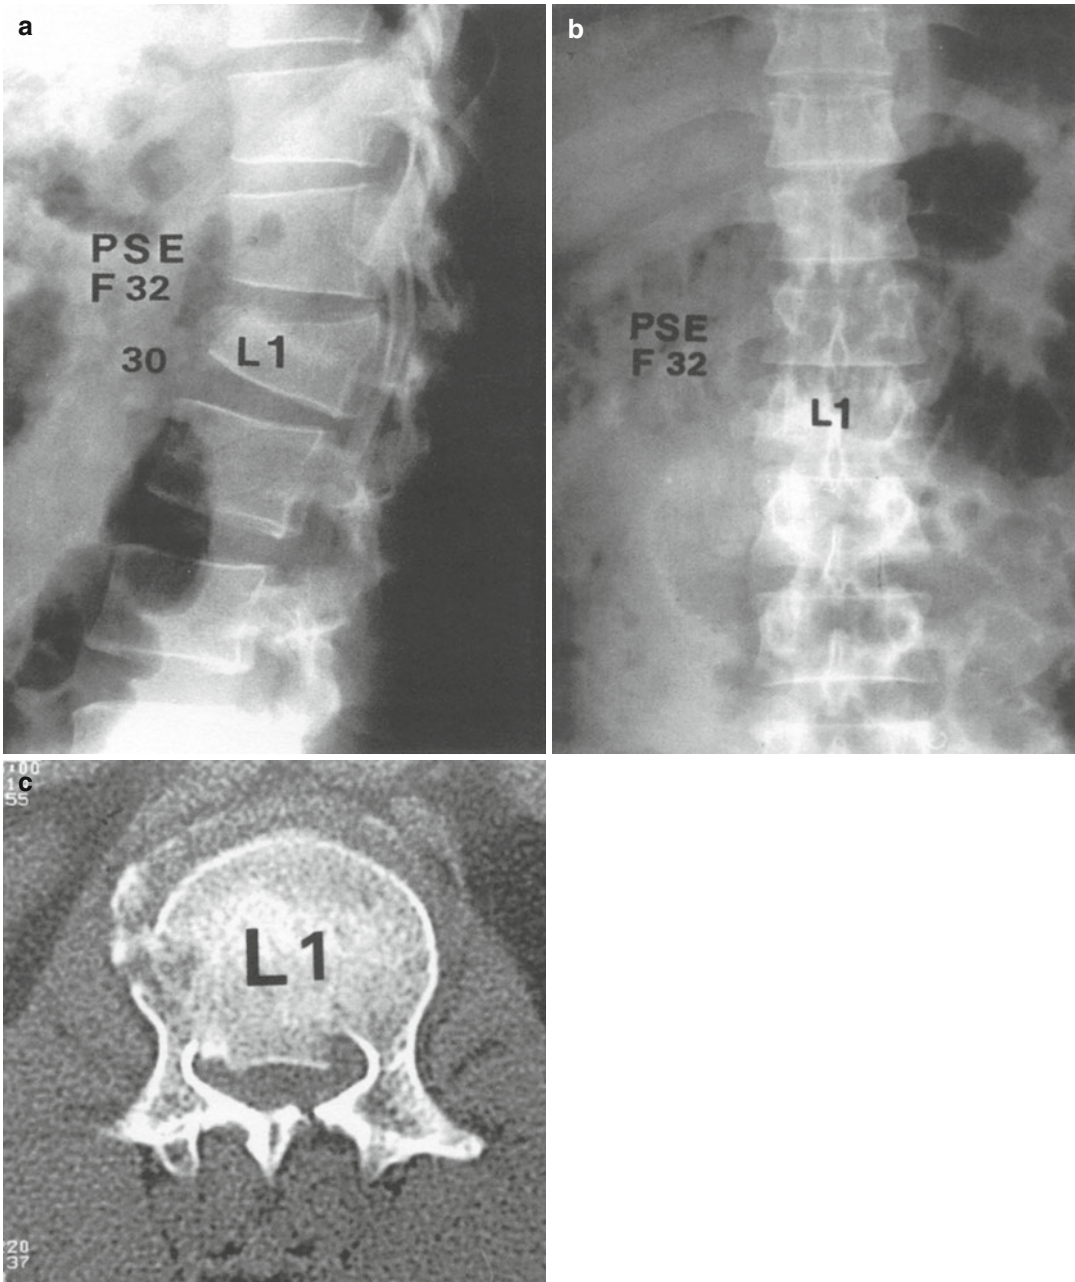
(a, b) A 32-year-old female with L1 unstable burst fracture at vertebra. Preoperative neurology was intact except for bowel and bladder control. There was a 30° kyphotic deformity at the thoracolumbar junction. (c) Preoperative CT show 60 % canal encroachment. (d, e) She was treated by the posterior fusion with pedicle screw fixation from T11 to L2. Following surgery, kyphosis was
